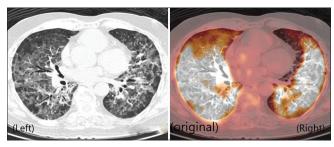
High-resolution computed tomography (left), and fused fluorodeoxyglucose positron emission tomography and high-resolution computed tomography (right) images reveals hypermetabolic ill-defined confluent ground-glass opacities with interstitial thickening near completely involving bilateral lungs
